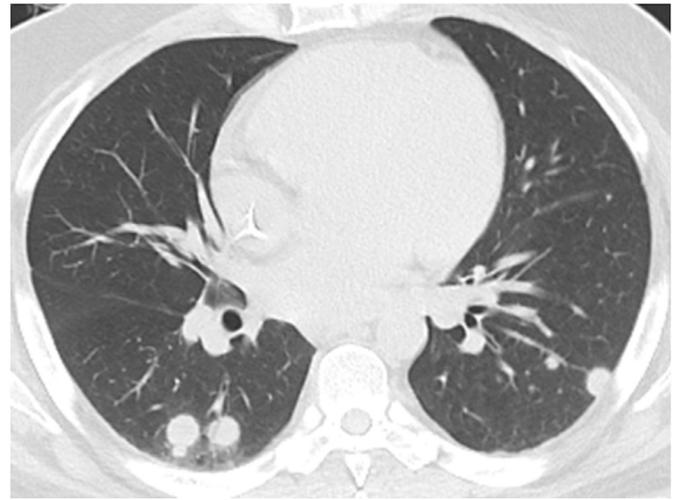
CMV pneumonia in an 18-year-old man with ALL who presented with fever, nausea, and vomiting 80 days post-HSCT. CT shows small nodular opacities, mild diffuse ground-glass opacities, and mild interlobular septal thickening. There is a small right pleural effusion. CMV = cytomegalovirus.
